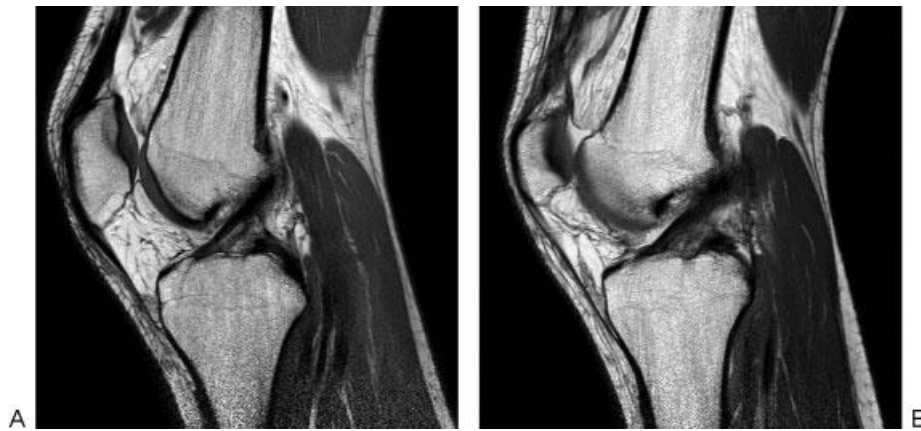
(A, B) Respectively proton density and T2-weighted magnetic resonance imaging (MRI) at the age of 14 years, 6 years after the initial MRI, showed normal delineation of the anterior cruciate ligament.
